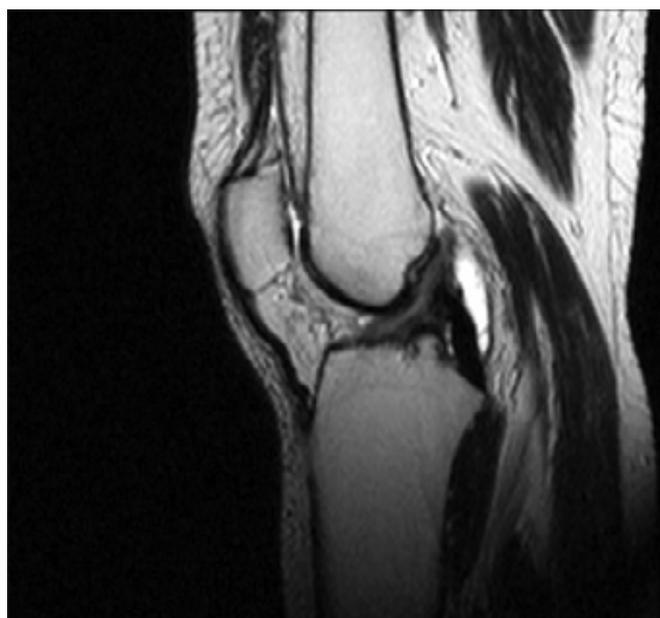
Sagittal T2-weighted MRI demonstrating ACL tear
